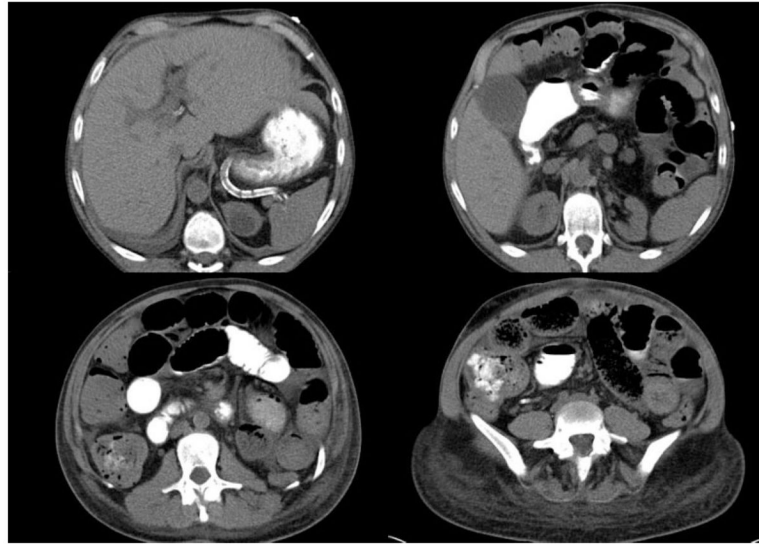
Abdominal CT of a 45-year-old woman with cystic fibrosis (CF) who had undergone bilateral lung transplantation 16 years prior. She presented with nausea, vomiting, abdominal pain, and distension and was ultimately diagnosed with distal intestinal obstruction syndrome. The CT shows diffusely dilated small bowel with inspissated material in the distal ileum. Of note, the pancreas is atrophic as is often seen in adult CF patients.
